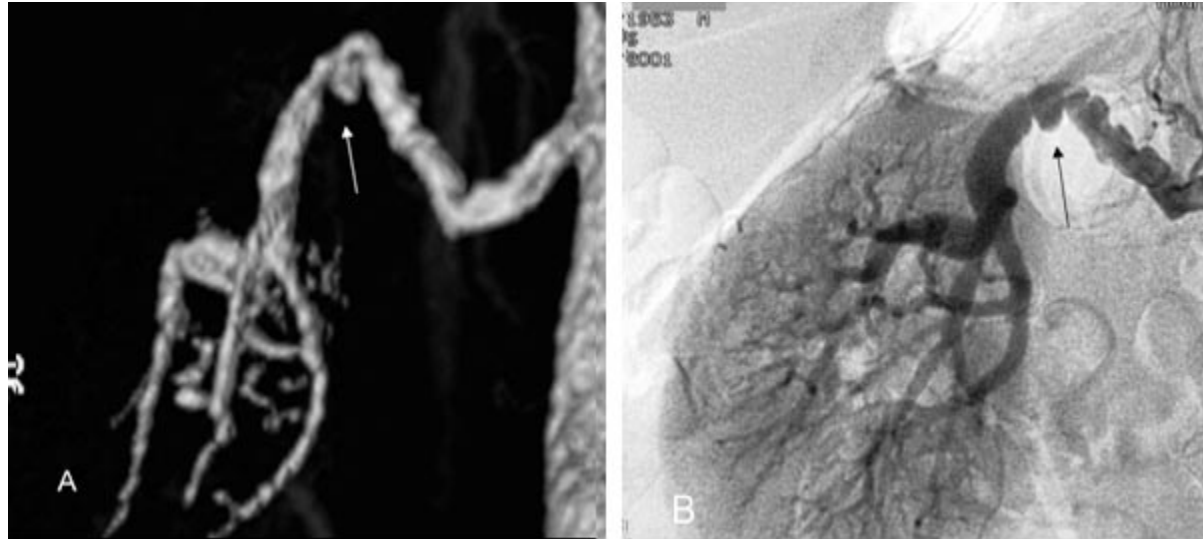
(A) CE MRA, shows heading of the right renal artery in a patient with fibromuscular dysplasia (FMD). (B) Corresponding X-ray angiogram in the same patient.
